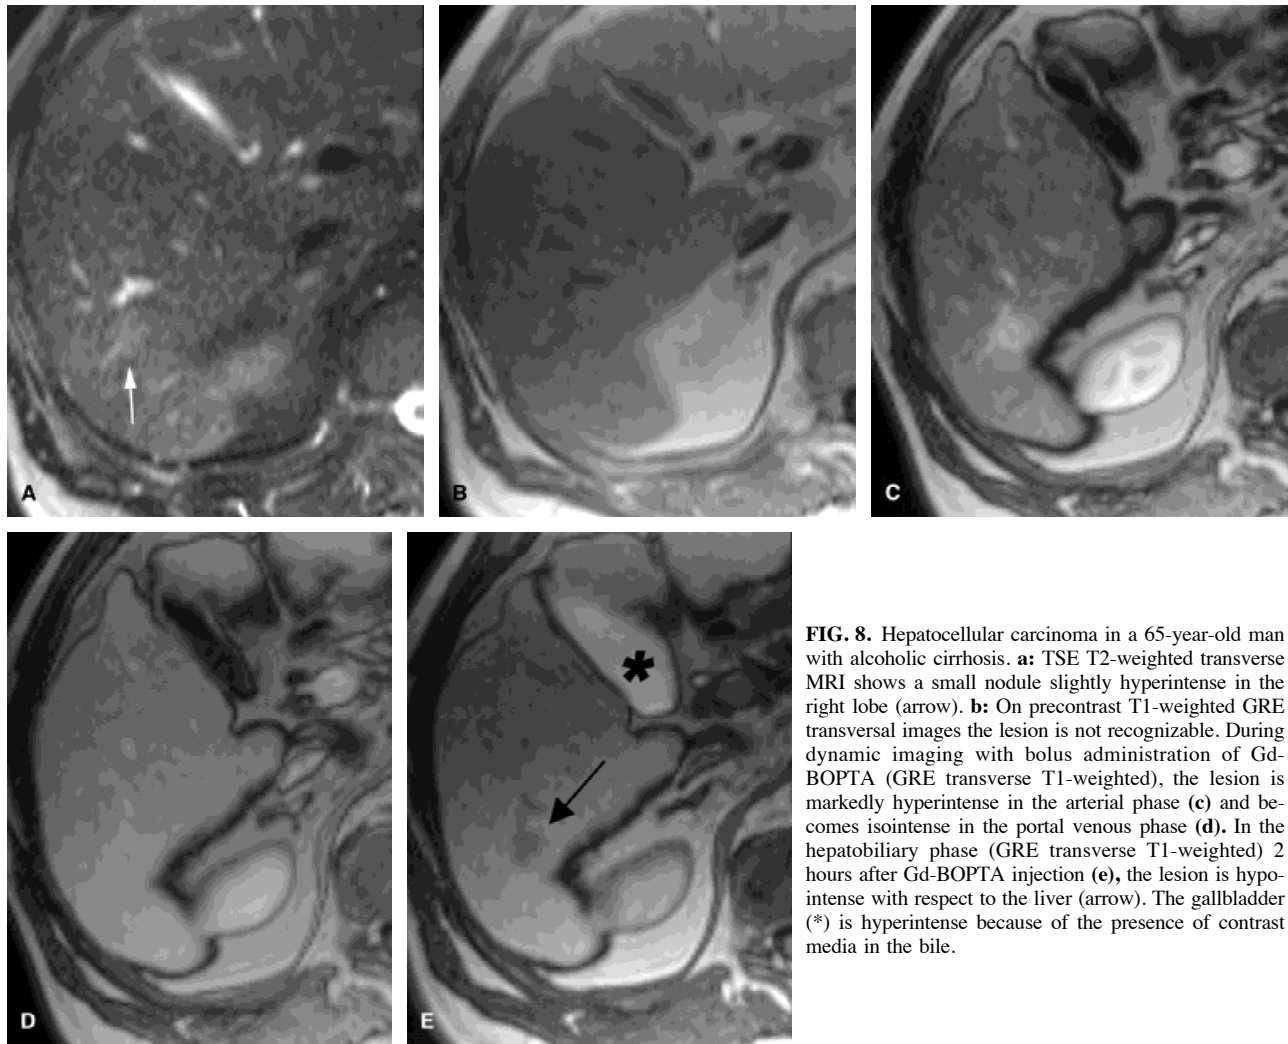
Hepatocellular carcinoma in a 65-year-old man with alcoholic cirrhosis. a: TSE T2-weighted transverse MRI shows a small nodule slightly hyperintense in the right lobe (arrow). b: On precontrast T1-weighted GRE transversal images the lesion is not recognizable. During dynamic imaging with bolus administration of Gd-BOPTA (GRE transverse T1-weighted), the lesion is markedly hyperintense in the arterial phase (c) and becomes isointense in the portal venous phase (d). In the hepatobiliary phase (GRE transverse T1-weighted) 2 hours after Gd-BOPTA injection (e), the lesion is hypointense with respect to the liver (arrow). The gallbladder (*) is hyperintense because of the presence of contrast media in the bile.
